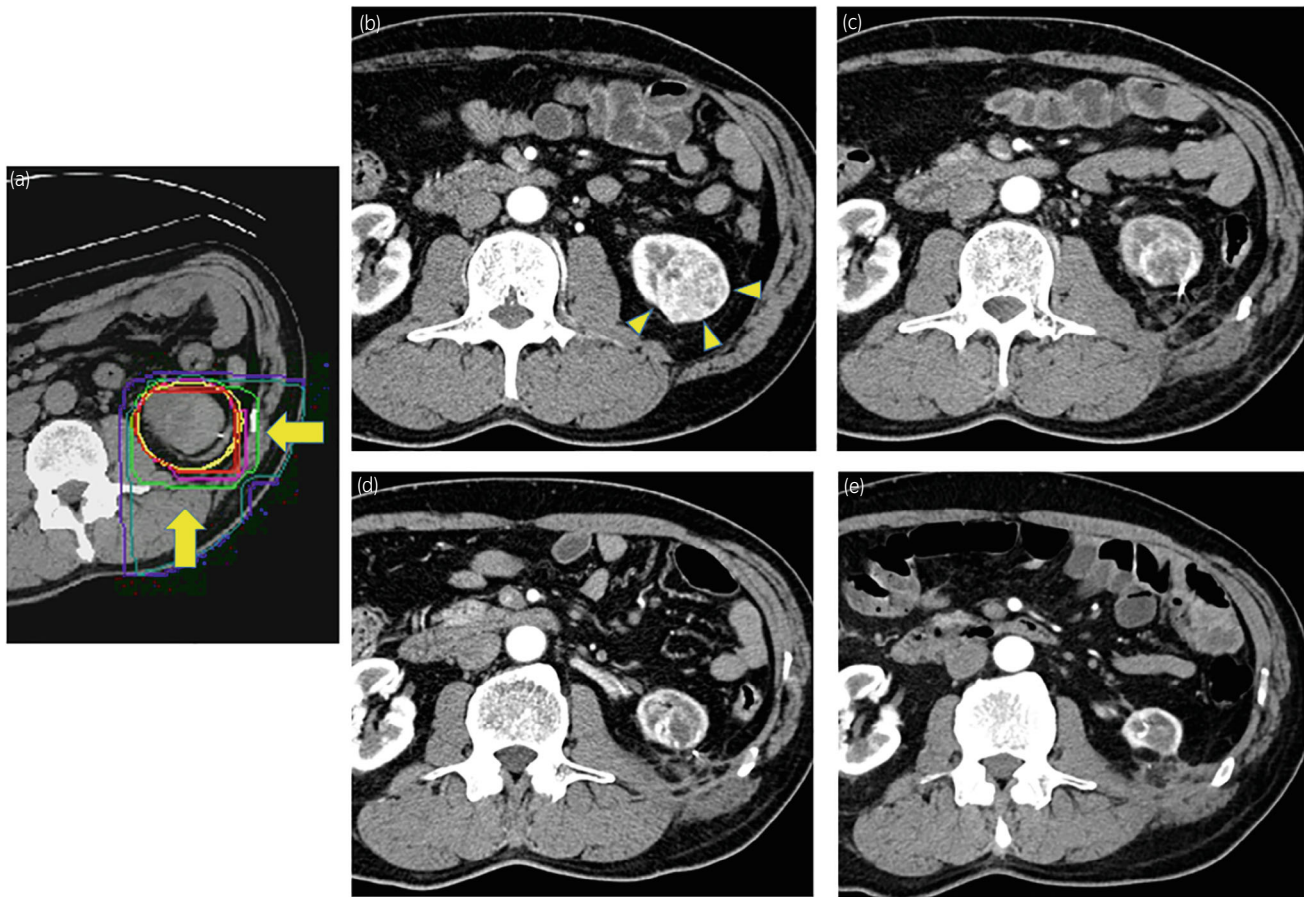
A representative RCC case after CIRT. Dose distribution of CIRT (a), and changes in a tumor on CT images at before (b) and 1 (c), 3 (d), and 10 (e) years after CIRT
